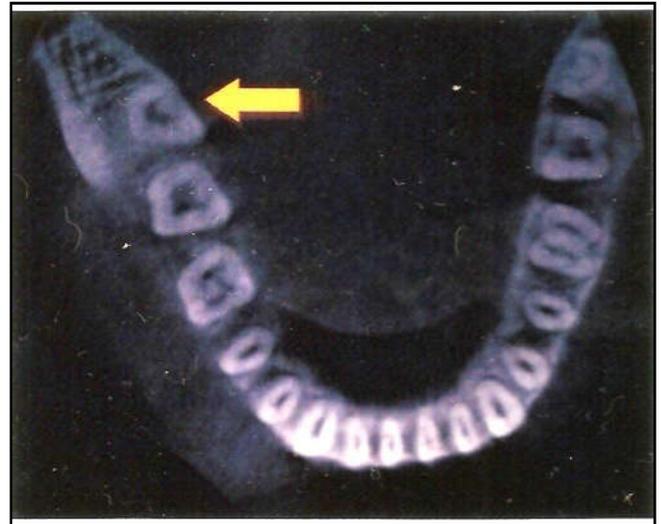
CBCT imaging showing the C – shape canal in mandibular third molar
